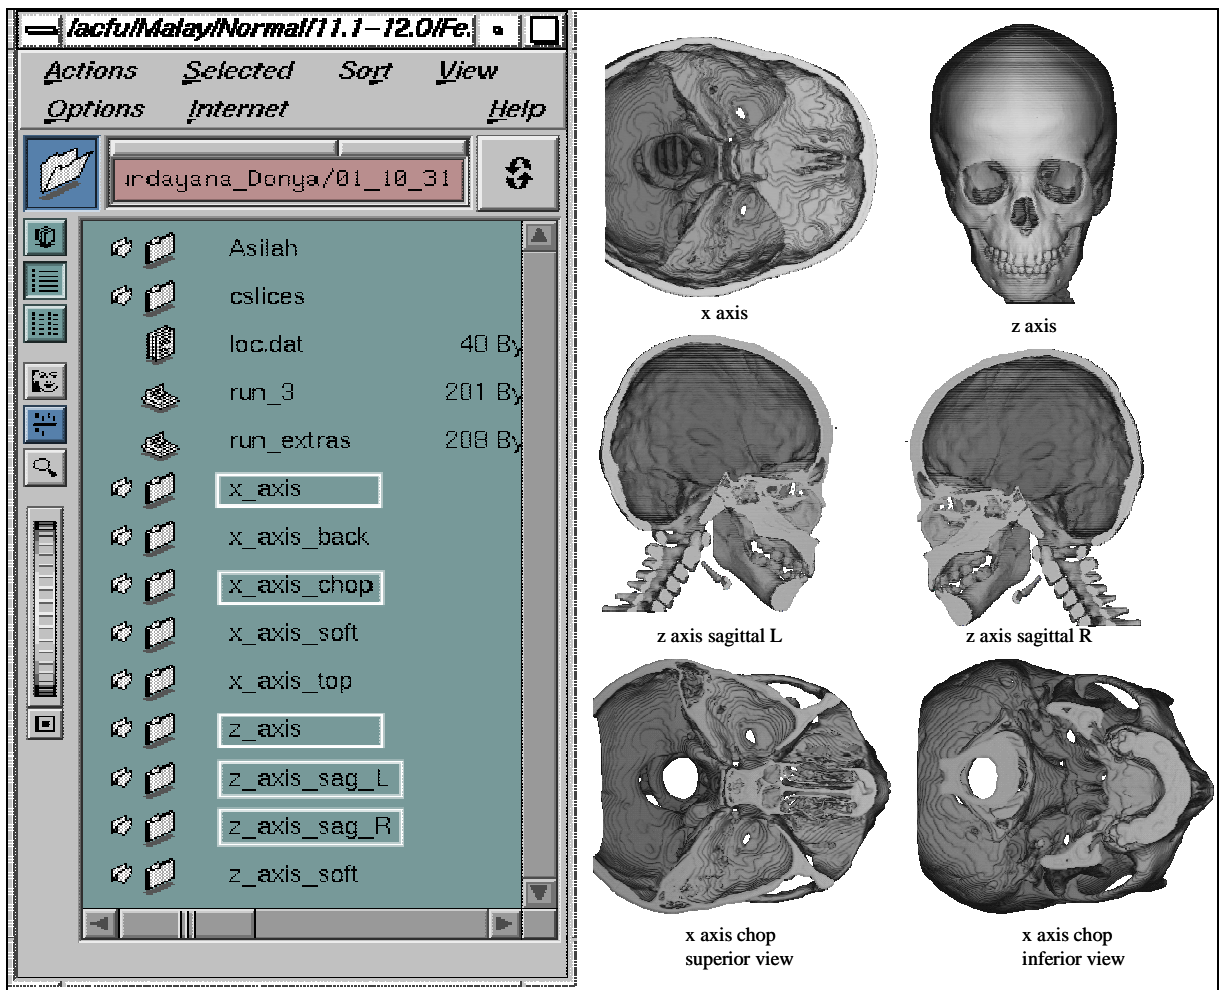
The clipped CT data in slice format were rendered to produce 3D images. The usual 3D images rendered are those outlined. X axis chop was usually performed at the stage of landmark determination. The other file directories contained instructions for rendering if required.
